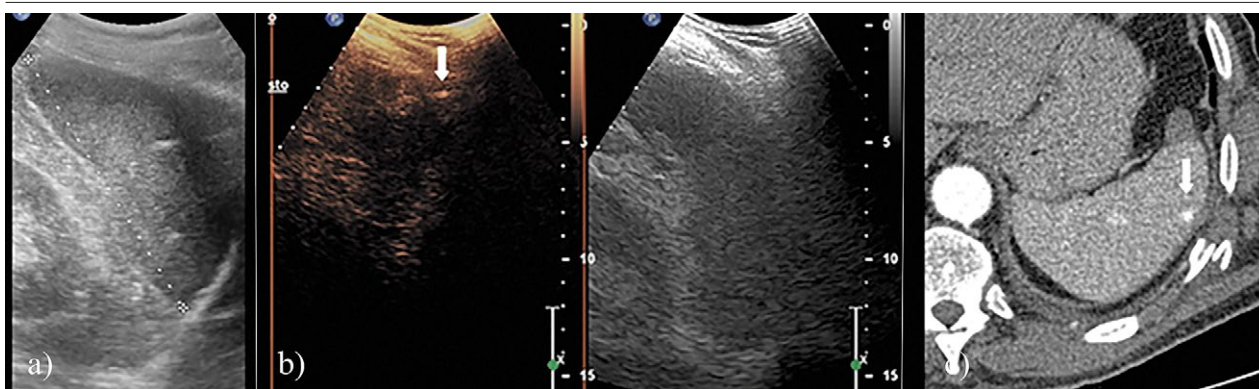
A 35-year-old man with a false negative conventional US (a) three days after trauma. CEUS examination, in the early arterial phase, raised the suspicion of a little pseudoaneurysm (arrow) (b) that was confirmed by subsequent CT scan (c).
